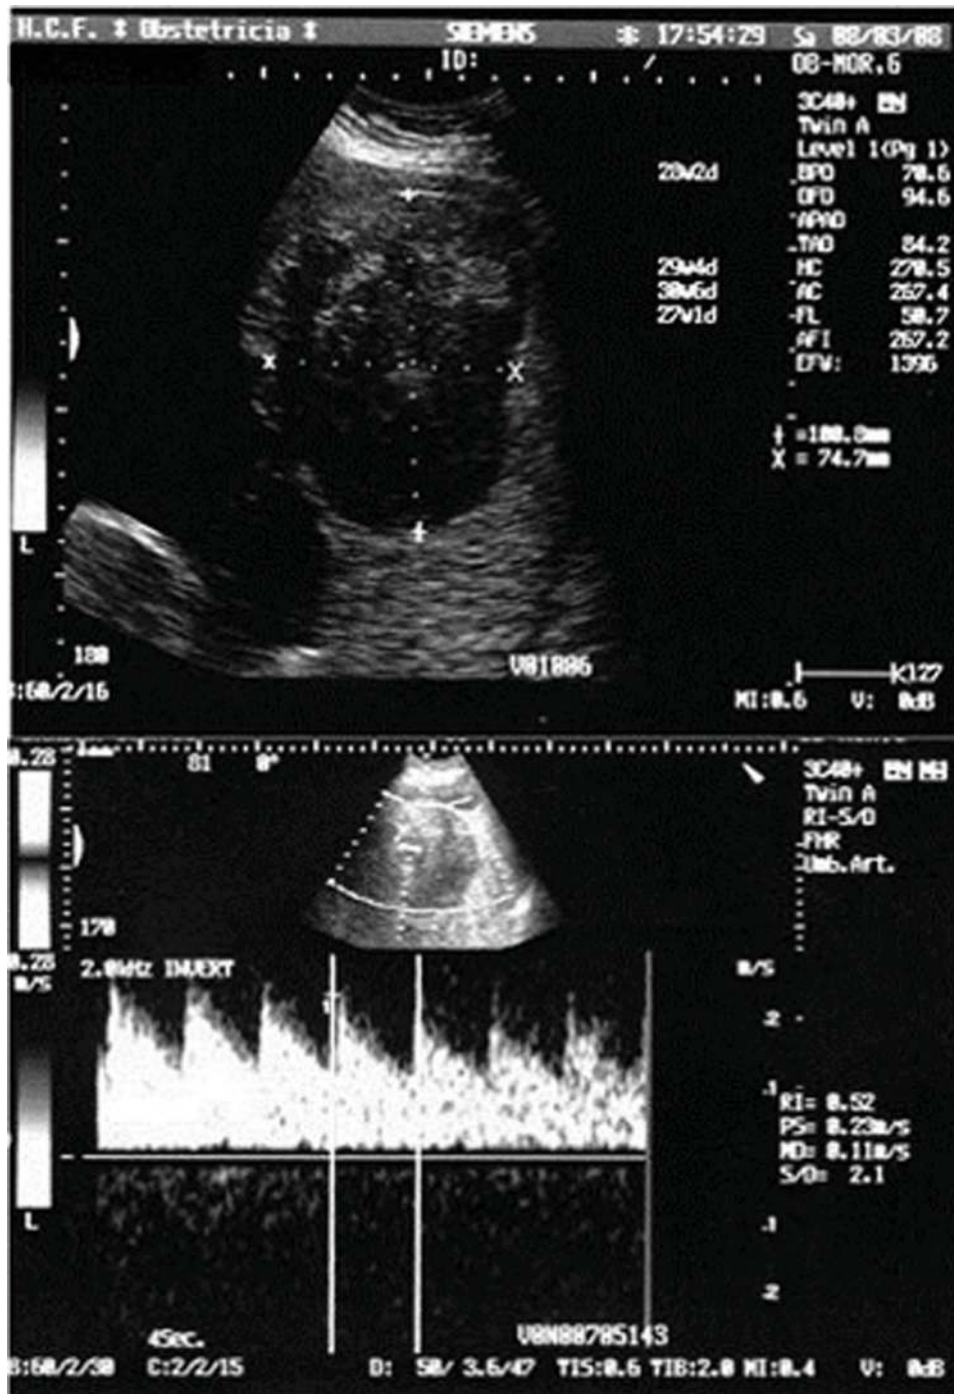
Ultrasonography showing a placental heterogeneous mass and flow velocity waveforms of vessels inside the placental tumour.
